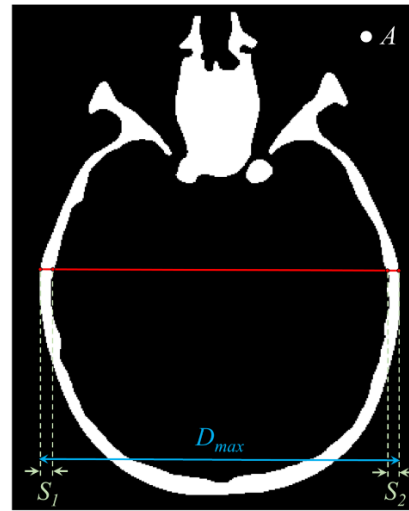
Mask of the CT slice in which the measured quantities being compared are shown. A : area of skull section (white pixels); D_{max} : maximum longitudinal diameter; S_1 and S_2 : skull thicknesses at D_{max} .
